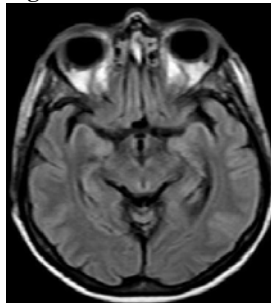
MRI brain 7 months prior
